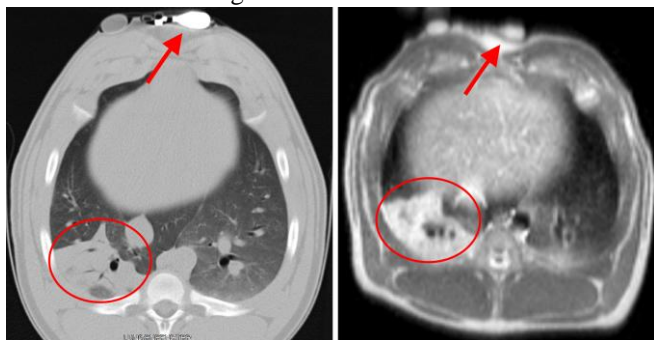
Validation of created NVAs (circled in red) with CAT-scan (left) and MRI (right). Marker verifies same plane (red arrow).
